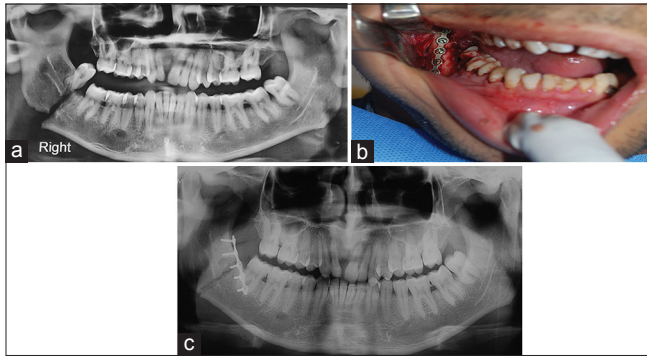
(a) Panoramic radiograph showing fracture of the mandibular angle (Right side); (b) nonlocking plate and screw applied on the superior border; (c) postoperative panoramic radiograph showing adequate reduction and fixation
